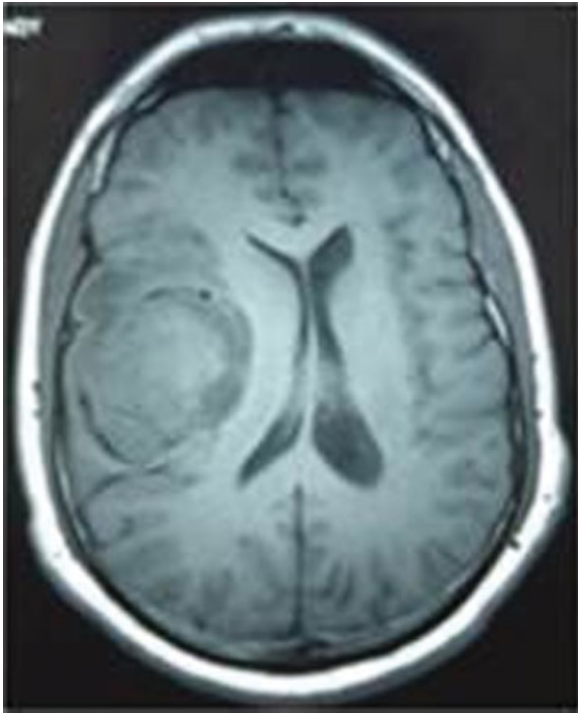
Axial T1-weighted image reveals a well-defined mass that is isointense with the brain.
